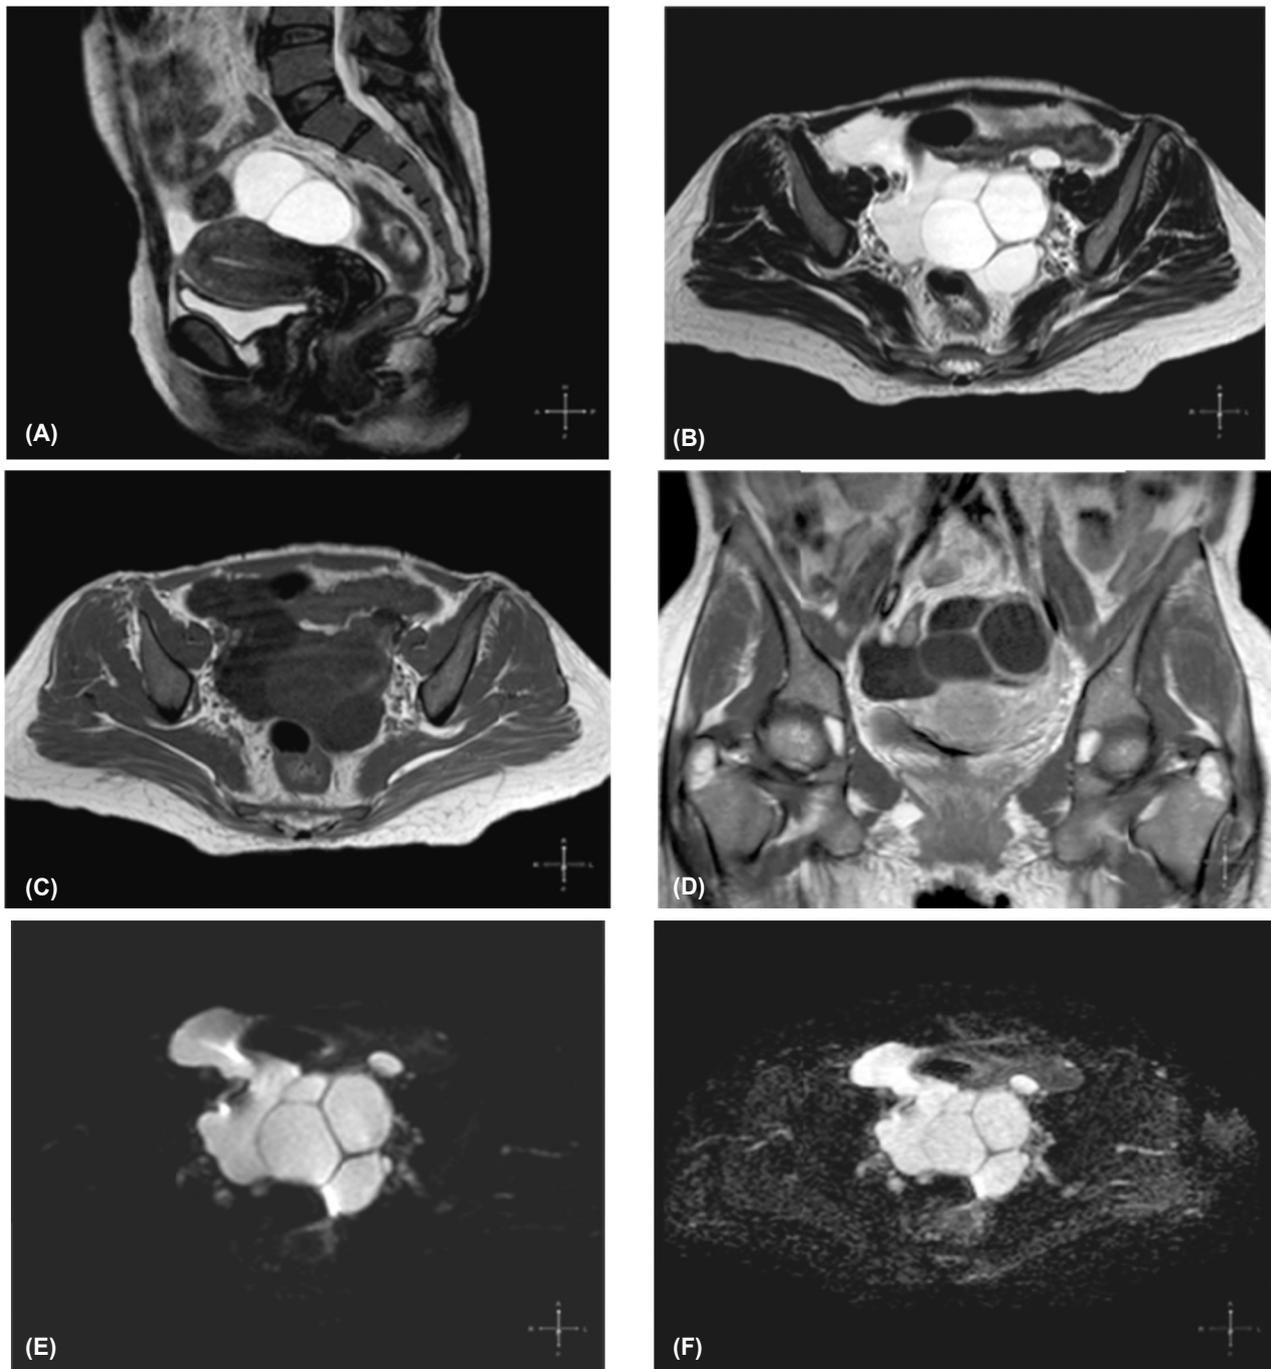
Female patient aged 42 years, with large multilocular cystic lesion on ultrasound. (A) Sagittal T2 WI, (B) Axial T2 WI, (C) Axial T1 WI, (D) Axial T1 post-contrast (E) DWI (b-value= 1000 sec/mm^2), (F) ADC map. A large multilocular left adnexal cystic lesion with low signal in T1, high signal in T2 (fluid signal). It shows thin septations ($<3 \text{ mm}$) which shows enhancement on the post-contrast images. Note the presence of free ascites in the axial T2 images. The lesion shows high signal on DWI and high signal of ADC map. The ADC value was $2.07 \times 10^{-3} \text{ mm}^2/\text{s}$. Final diagnosis: Serous cystadenoma.
